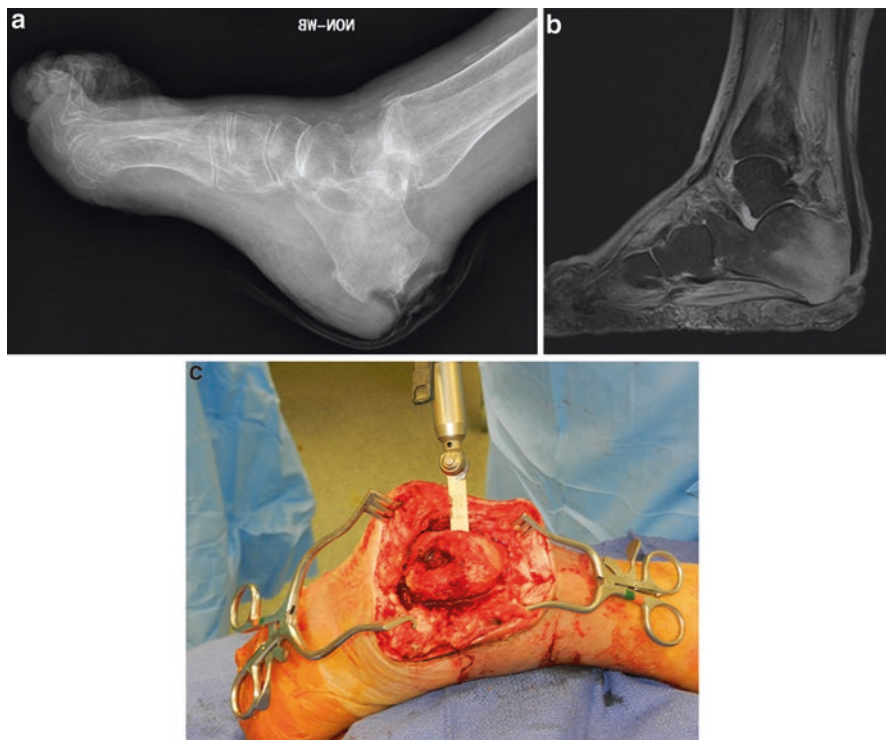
Partial calcaneotomy. (a, b) Preoperative x-ray and MRI showing soft tissue loss of the posterior hindfoot and extensive changes to the calcaneus consistent with osteomyelitis. (c) Intraoperative picture showing resection of part of the calcaneus
